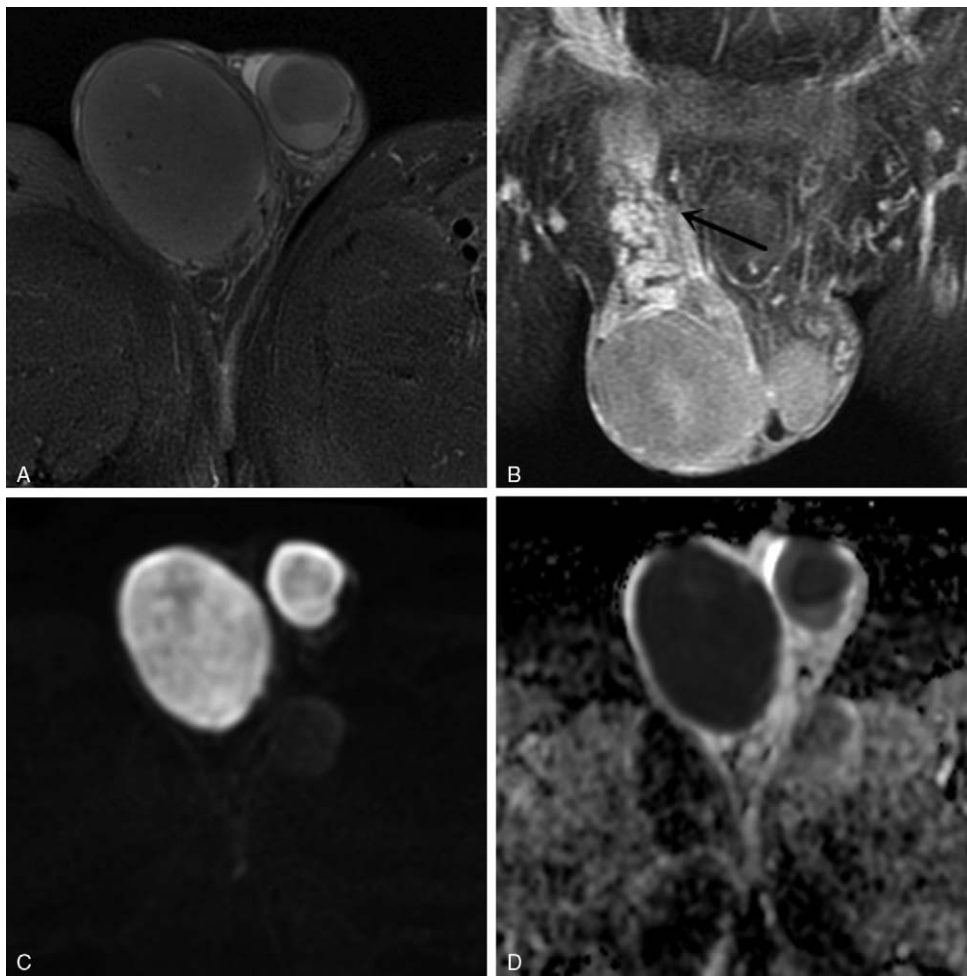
Images of a 63-year-old man with lymphoma in the bilateral testises. (A) Axial fat-suppressed T2-weighted image shows bilateral round-like tumors with hypointense signal. (B) Axial arterial phase fat-saturated gadolinium-enhanced T1-weighted image displays bilateral tumors with homogeneous enhancement and invasion of the right spermatic cord (arrow). (C) The bilateral masses present with heterogenous hyperintense signal on the DWI and heterogenous hypointense signal on the ADC image (D) with a mean value of $0.35 \times 10^{-3} \text{ mm}^2/\text{s}$ (right), $0.48 \times 10^{-3} \text{ mm}^2/\text{s}$ (left). ADC = apparent diffusion coefficient.
